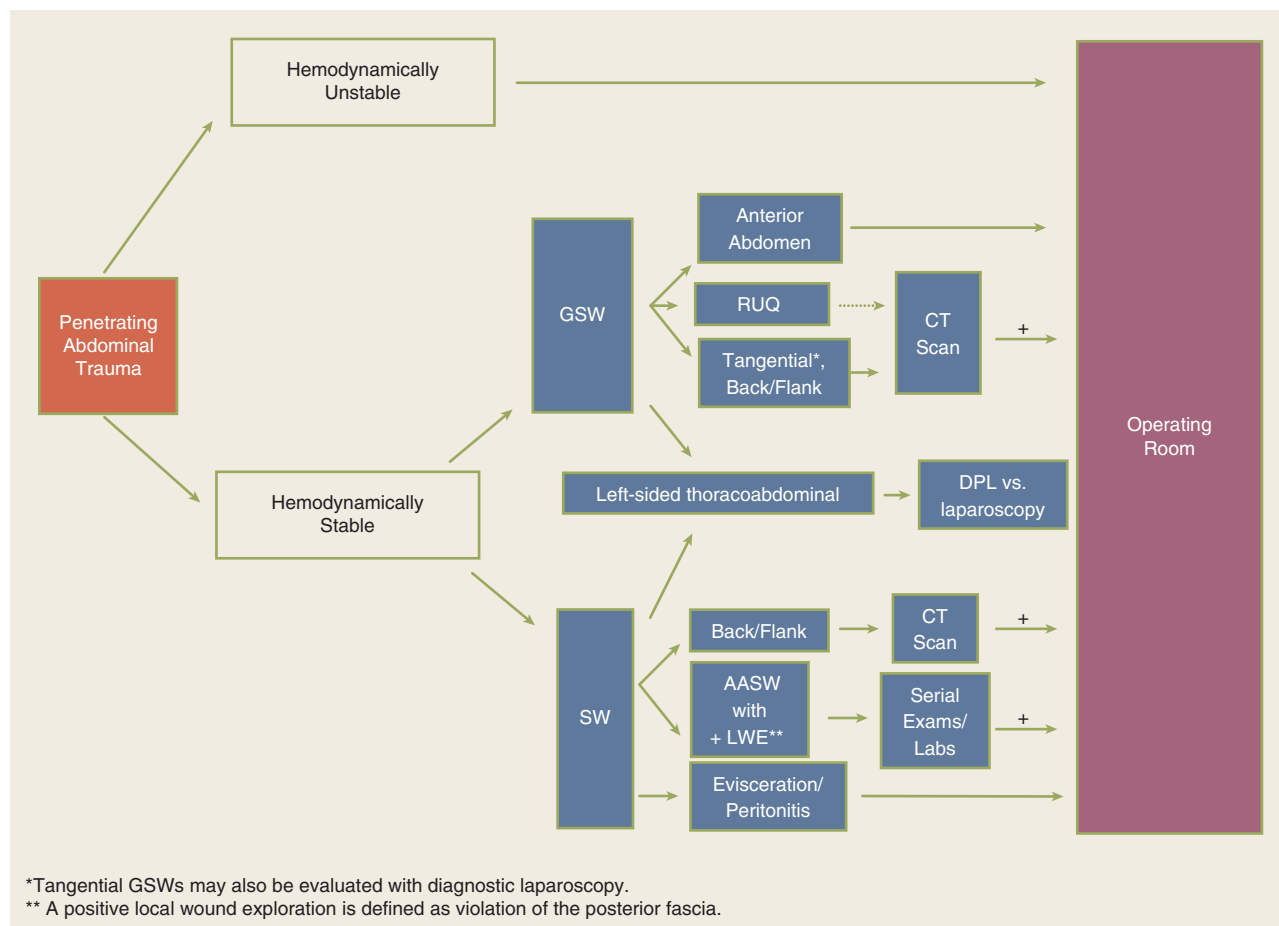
Algorithm for the evaluation of penetrating abdominal injuries. AASW = anterior abdominal stab wound; CT = computed tomography; DPL = diagnostic peritoneal lavage; GSW = gunshot wound; LWE = local wound exploration; RUQ = right upper quadrant; SW = stab wound.
